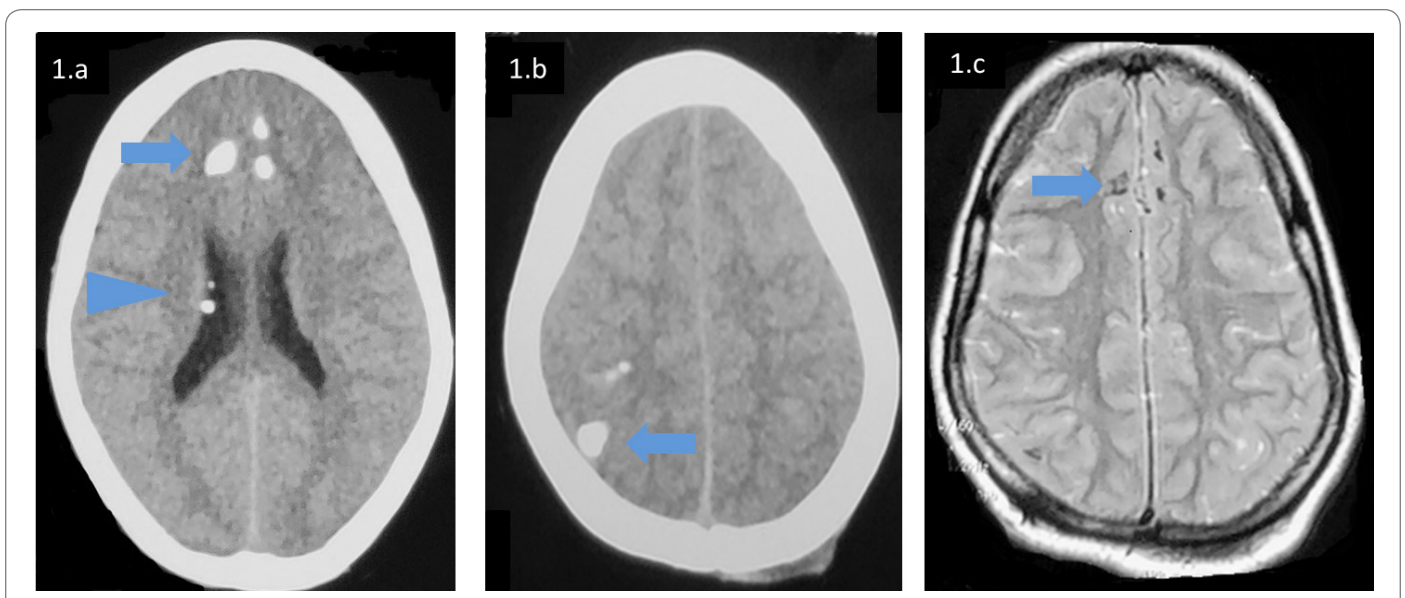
CT Head of first child showed calcified tubers (1a, 1b, blue arrow) and calcified SENs (1a, blue arrow head), MRI Brain (1c) showed T2 hypointense (calcified) tubers.
